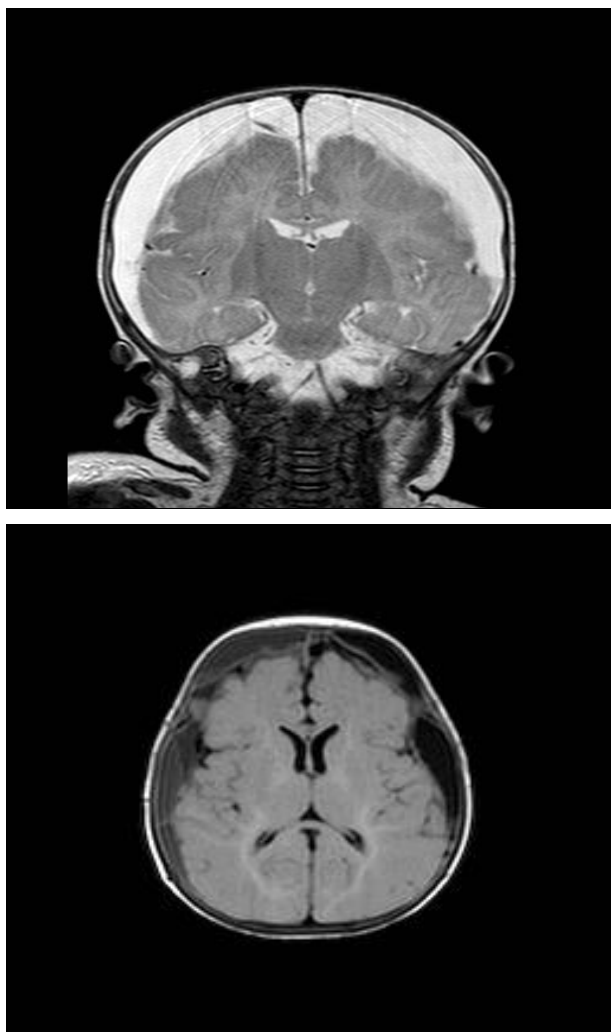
1A y 1B: MRI T2 and T1 sequences in coronal plane (1A) and axial plane (1B) showing bilateral subdural empyemas
